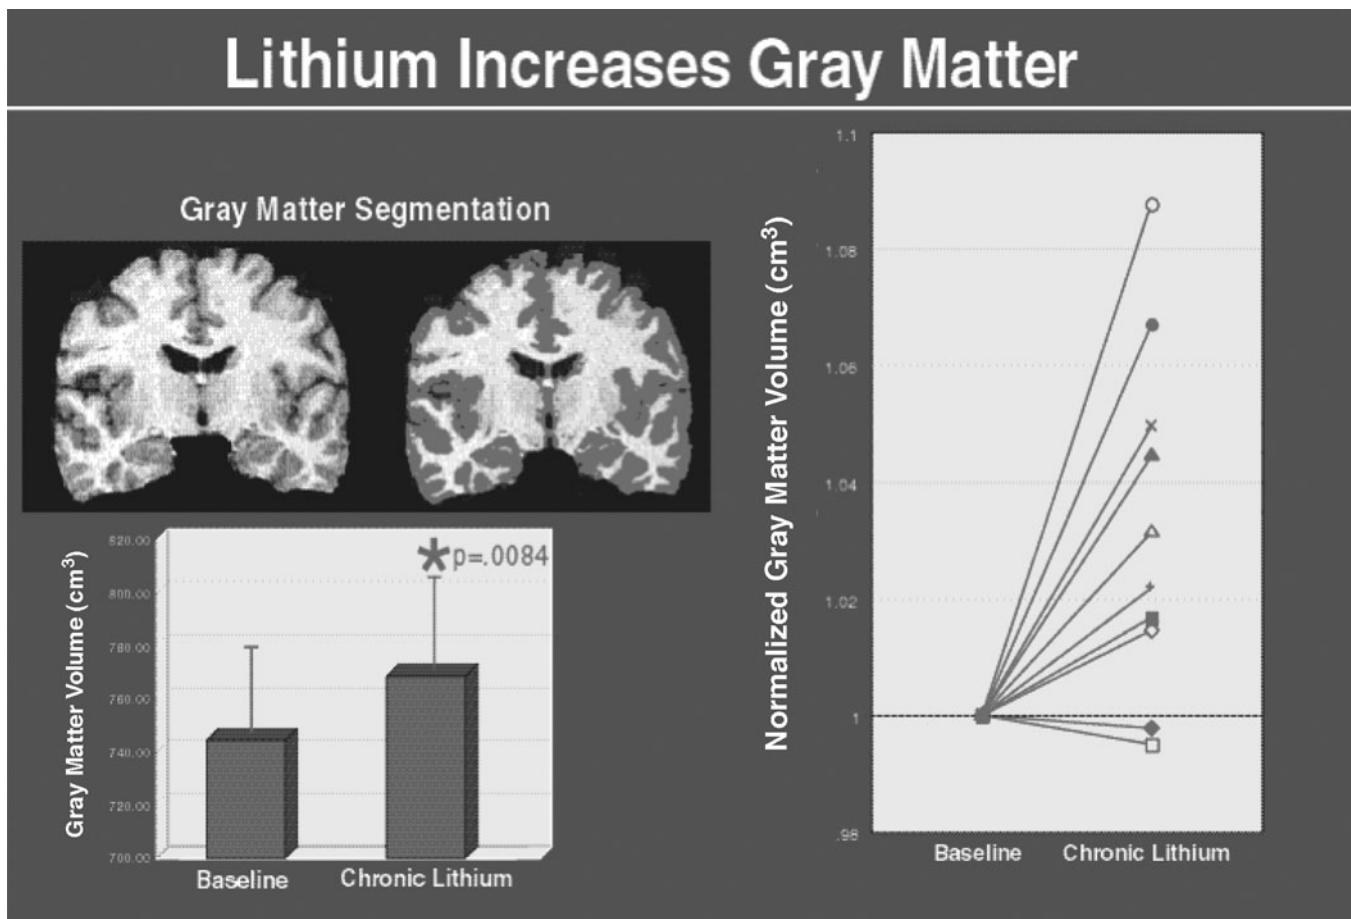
Brain gray matter volume is increased following 4 weeks of lithium administration at therapeutic levels in patients with bipolar disorder. Brain tissue volumes were examined by means of high-resolution three-dimensional MRI and validated quantitative brain tissue segmentation methodology to identify and quantify the various components by volume, including total brain white and gray matter content. Measurements were made at baseline (medication-free, after a minimum 14-day washout) and then repeated after 4 weeks of lithium at therapeutic doses. Chronic lithium significantly increases total gray matter content in the human brain of patients with bipolar disorder. No significant changes were observed in brain white matter volume or in quantitative measures of regional cerebral water. (Source: Gould and Manji, 2002b. Reprinted by permission of SAGE Publications, Inc.)
